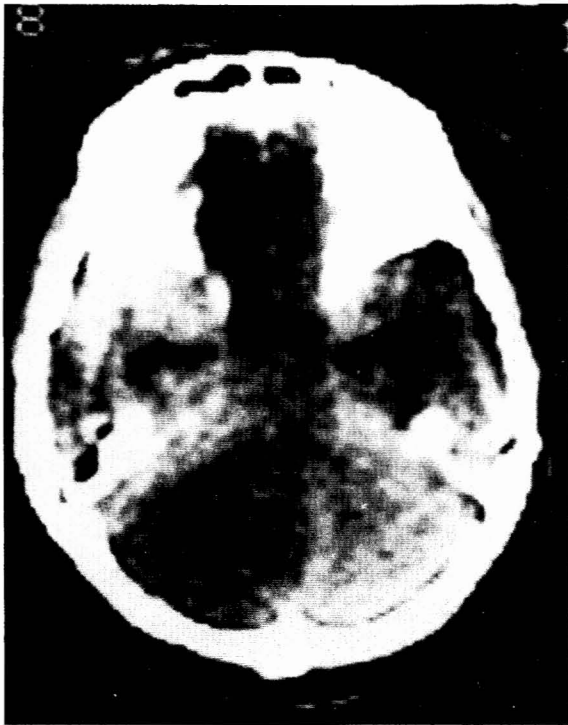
Case 1. CT scan showing a massive left cerebellar infarction. Comparison between the right and left cerebellar hemispheres shows a large, low density area in the left cerebellar hemisphere.
